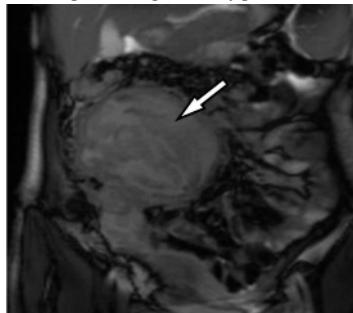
MRI coronal T2W image shows well defined lesions fine hyperintensities and hypointensities within mimicking hydatid membranes representing the wavy pattern of the gauge (arrow)
